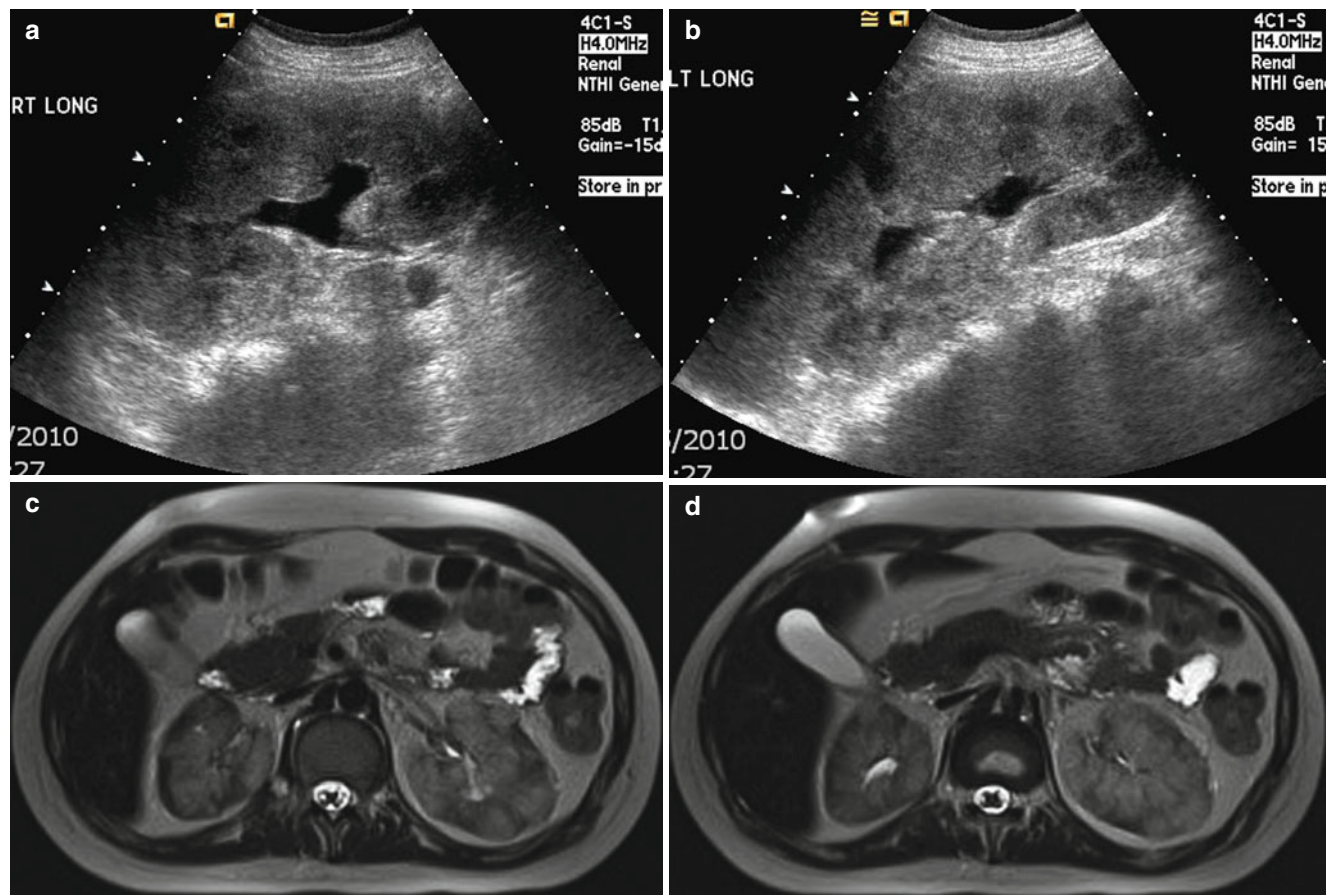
Leukemia in a 13-year-old boy. (a and b) Longitudinal US of both kidneys shows diffusely increased echotexture of renal parenchyma and multiple hypoechoic nodules. (c and d) T2-weighted axial
